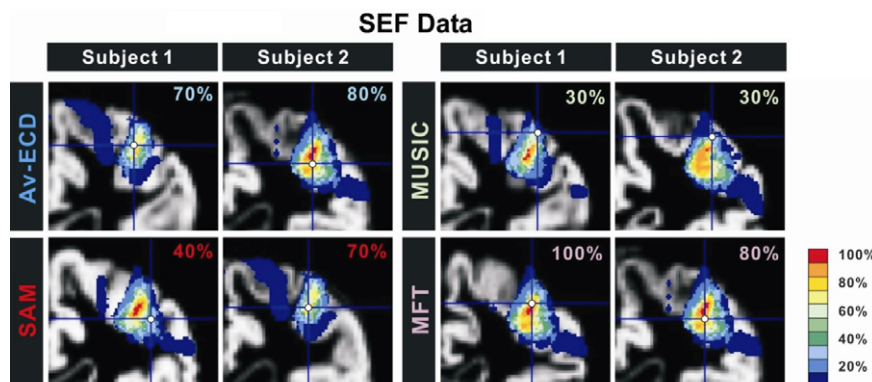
Correspondence of estimated generators to cytoarchitectonic areas for two subjects, subject 1 on the left and subject 2 on the right. Rows show the results for source localisation methods for left wrist stimulation. The source estimates are over-plotted on each subject's MRI and the probabilistic cytoarchitectonic map for Brodmann area 3b.
